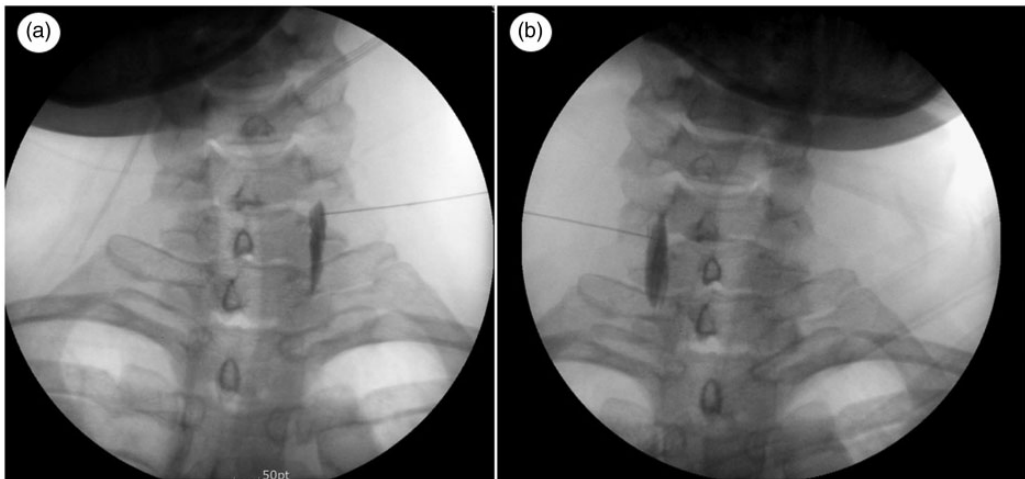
Radiographic imaging at the time of botulinum toxin injection. Anteroposterior view of the needle positions and the spreading of contrast material. The contrast material is spread along the longus colli muscle. (a) Left longus colli muscle. (b) Right longus colli muscle.
